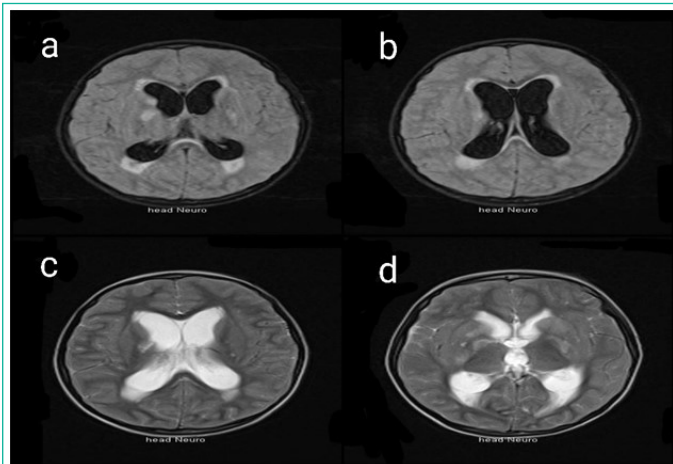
(a,b) Axial T1-weighted image with dilated lateral ventricles. (c,d) Axial T2-weighted image with dilated lateral ventricles.
